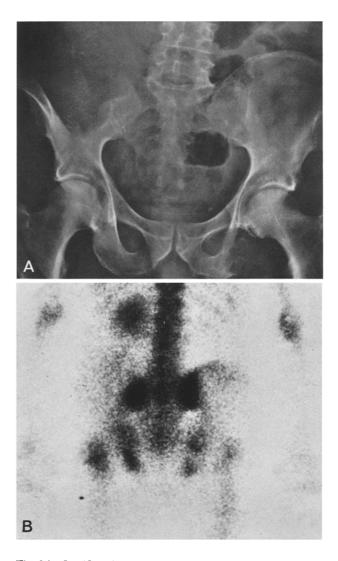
Negative scan associated with superaggressive metastases of renal cell carcinoma. A Radiograph reveals extensive lytic "blown out" metastases in right ilium and left ischium. B Scan reveals that huge right ilial metastasis has relatively low level of radionuclide activity while left ischial metastasis is less active than normal right ischium. Metastatic lesion in the right proximal femur with moderate activity is depicted on scan but not in radiograph
